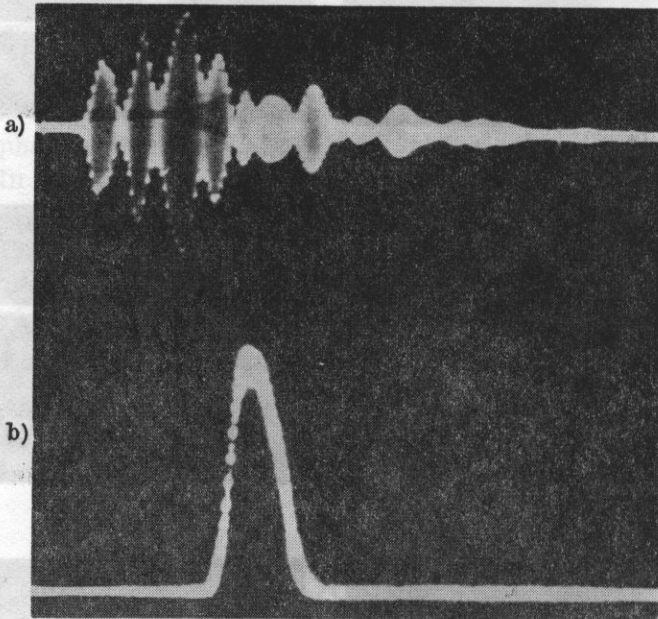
Ultrasonic echoes at the input of the SEC system obtained in the investigation of blood flow in the common carotid artery (a) and a flow profile in this artery after cancellation of stationary echoes above 55 dB (b)
